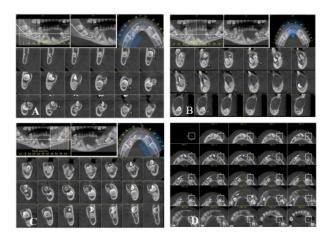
CBCT scan. (A-C) Cross-sectional sections and (D) axial sections showing hypodense corticated area with multiple impacted teeth.
